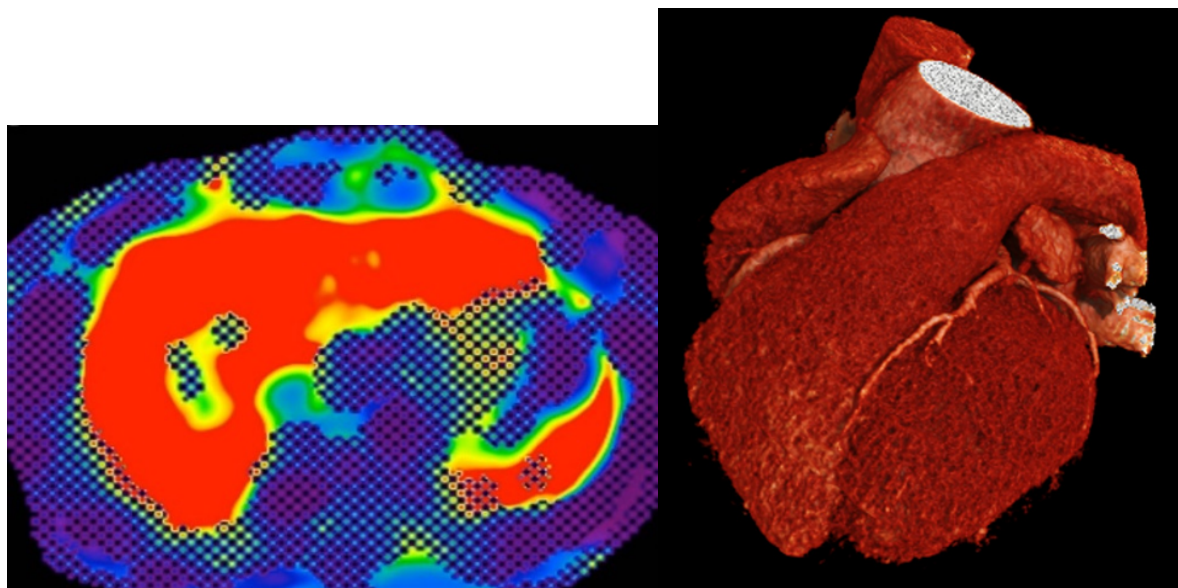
Left: Example image of MRI Elastography, Right: Example image of CCTA
